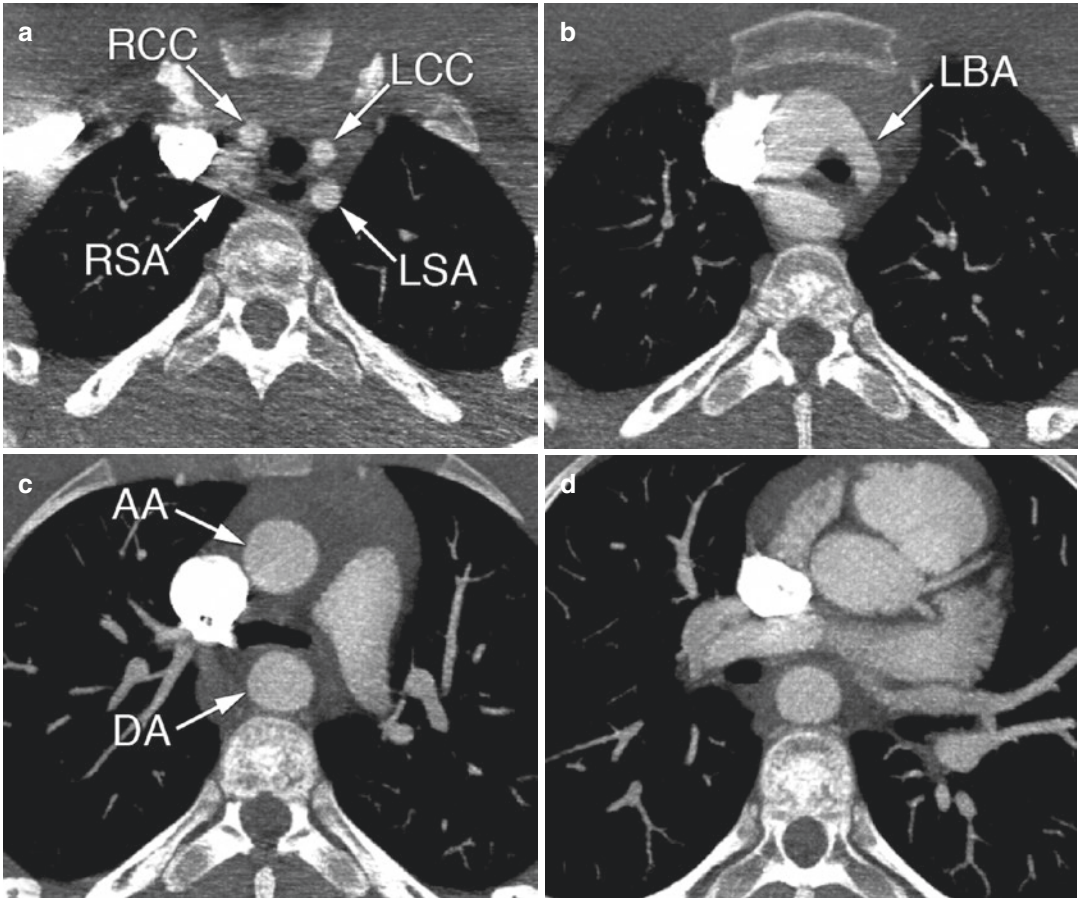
Double-aortic arch with atretic segment. 14-year-old male patient with recurrent pulmonary infection. CT angiography showing complete vascular ring: Double-aortic arch with large right arch and small left arch with an atretic segment (fibrous strand) in connection to the descending aorta. The ring causes tracheal narrowing. Left upper panel above arch level with the typical four
